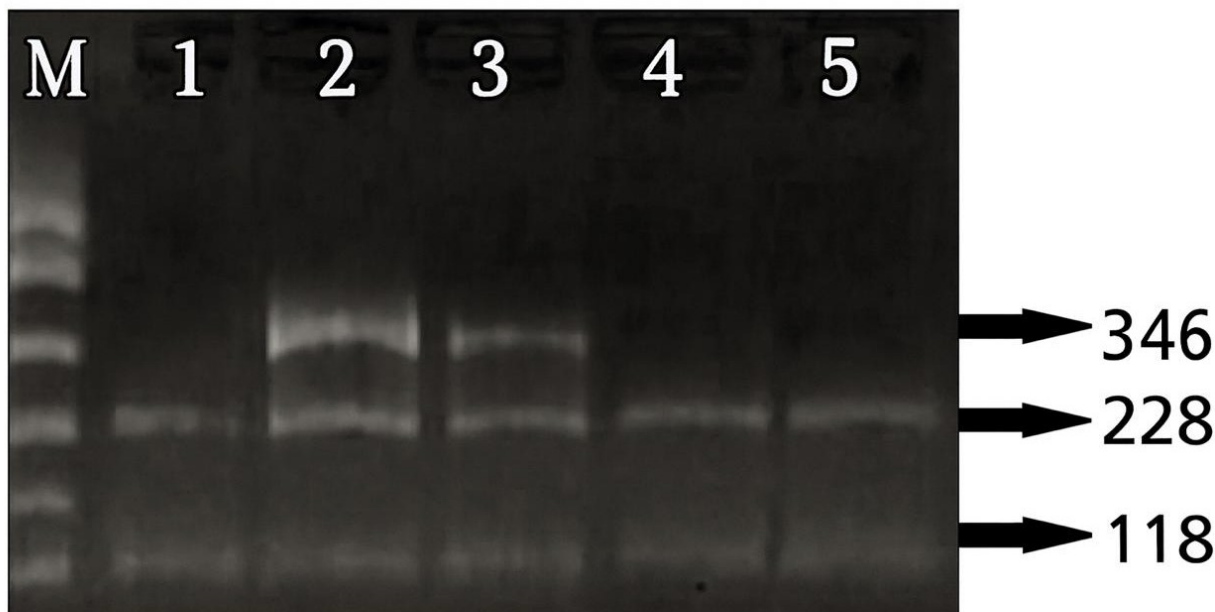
Agarose gel electrophoresis of the RFLP analysis for the *HIF-1 α* C1772T (rs11549465) polymorphism. The heterozygous CT genotype produced three DNA fragments of 346, 228, and 118 base pairs (lanes 2 and 3), while the homozygous CC genotype produced two fragments of 228 and 118 base pairs (lanes 1, 4 and 5). A 50 bp DNA ladder was used as a molecular weight marker and is shown on the left. RFLP, restriction fragment length polymorphism; HIF-1 α , hypoxia-inducible factor-1 alpha.
